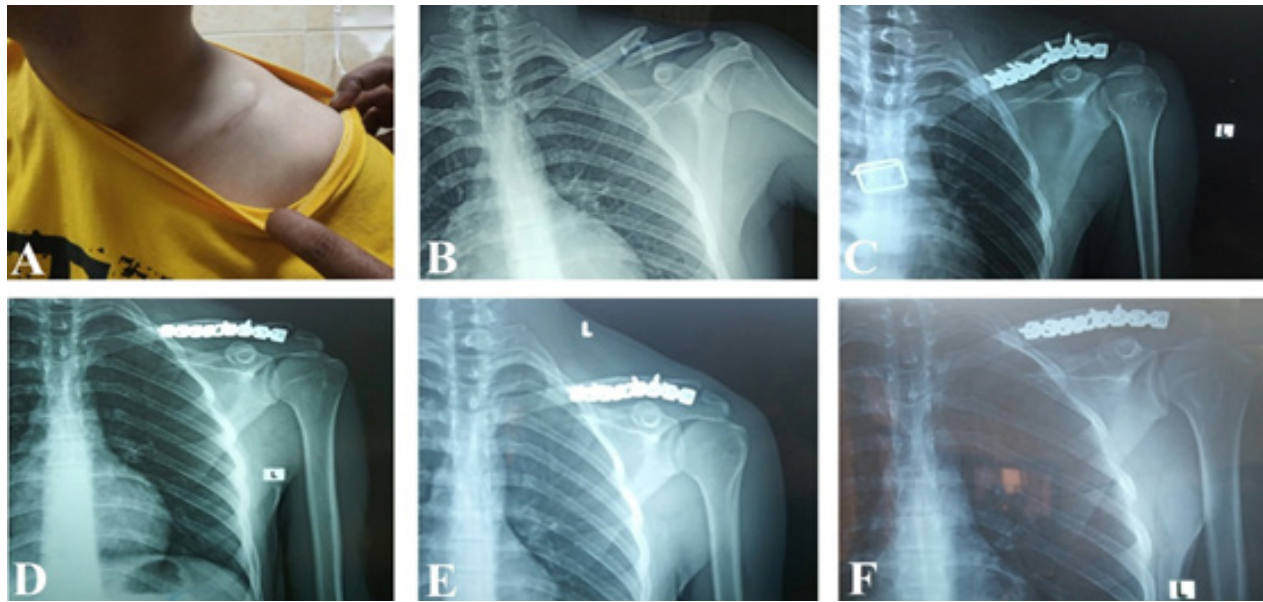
A 20-year-old delivery man with a displaced midshaft clavicle fracture. Open reduction and internal fixation was done using 3.5 reconstruction plate placed on the anteroinferior surface. Full union was achieved without complications; (A): Preoperative clinical photograph; (B): Preoperative radiography; (C): Postoperative radiography; (D): 2 weeks follow-up radiography; (E): 6 weeks follow-up radiography; (F): 6 months follow-up radiography.
